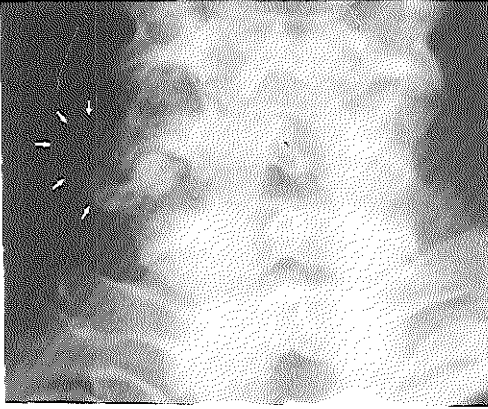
Plain radiography confirmed the ultrasound findings, showing a bony deformity of a cervical vertebra (arrows).
